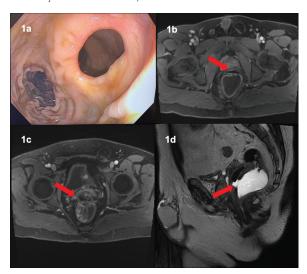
Endoscopic and MRI images of rectal duplication. a) Two lumens seen endoscopically. b) Duplication cyst anterior to the rectum merging with the rectum inferiorly at 4.5cm from anal verge. c) Duplication communicating to sigmoid. d) Retrograde contrast filled both lumens.
